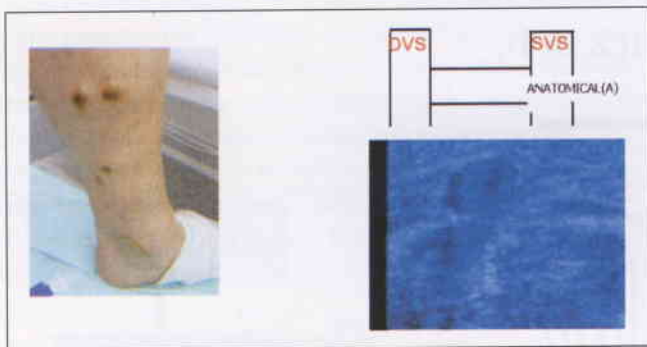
Anatomical perforator (A). No visible flow on ultrasound.
